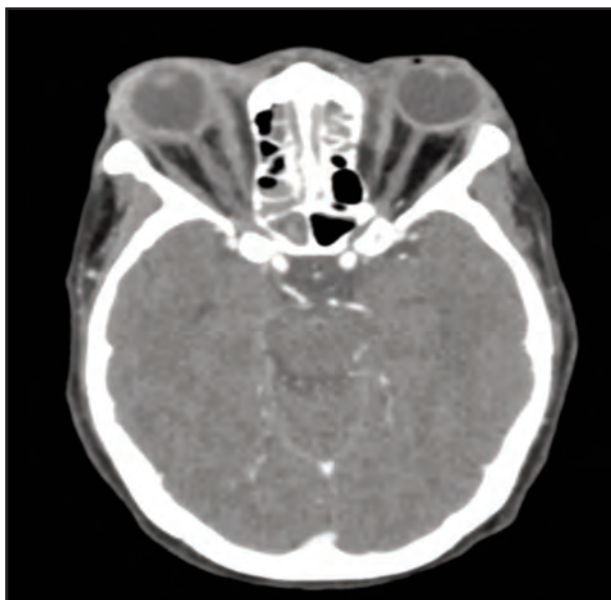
Computed tomography brain and orbit showed an irregular right eye globe with enhancement, swollen recti muscles, and a thickened optic nerve with intraconal fat streakiness left extraconal collection extended into intraconal region
